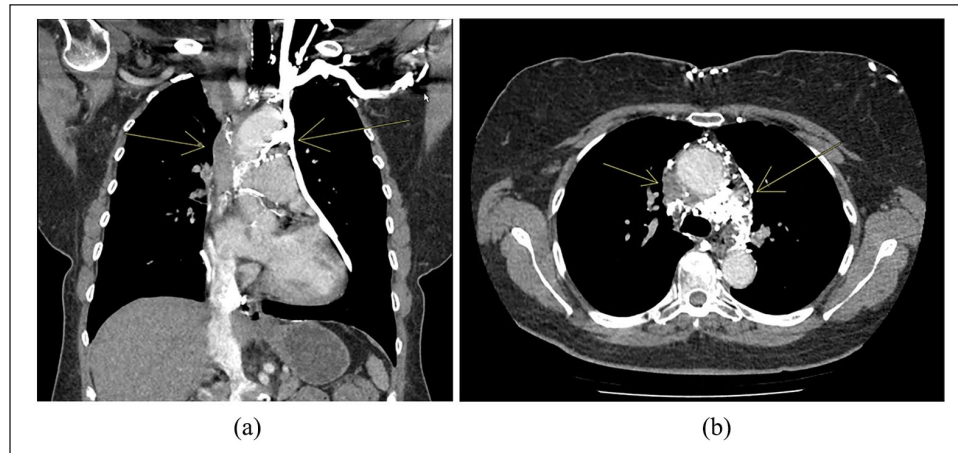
CT angiogram of the chest. (a) A coronal view and (b) an axial view, both show the occluded SVC (left-sided arrow on the patient's right) and the bright white opacified collaterals (right-sided arrow on the patient's left).
